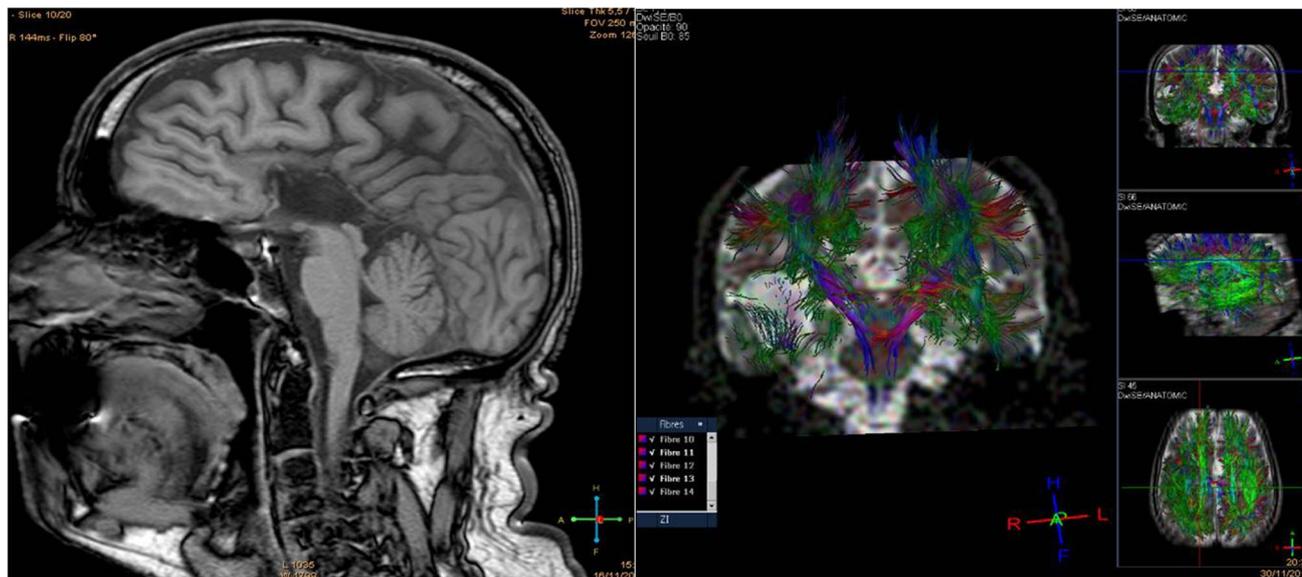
Left: Brain MRI, sagittal slice. T1-weighted sequence. Complete corpus callosum agenesis, with absence of anterior and posterior white commissures. Right: Brain MRI, axial slice. DTI sequences. Red lines correspond to the interhemispheric fibers, green
